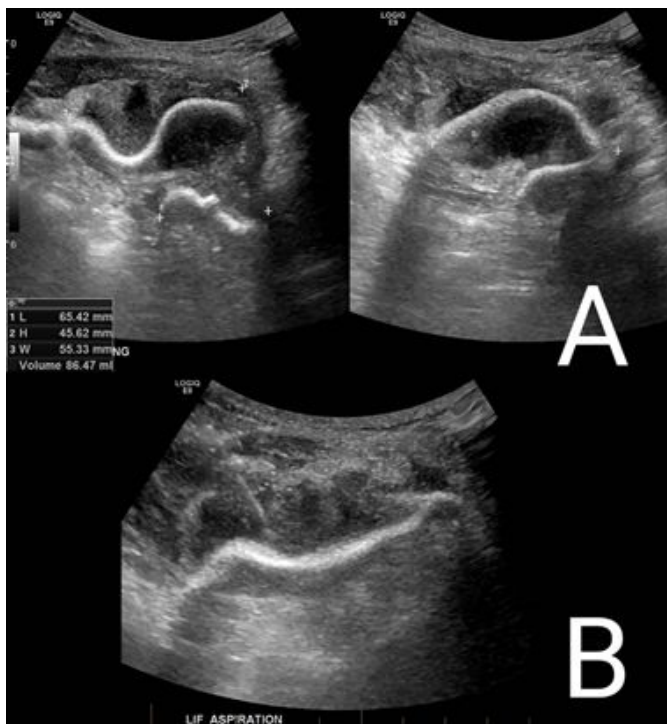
Ultrasound images of the collection with mesh (A) and ultrasound-guided aspiration of the collection above mesh (B).
